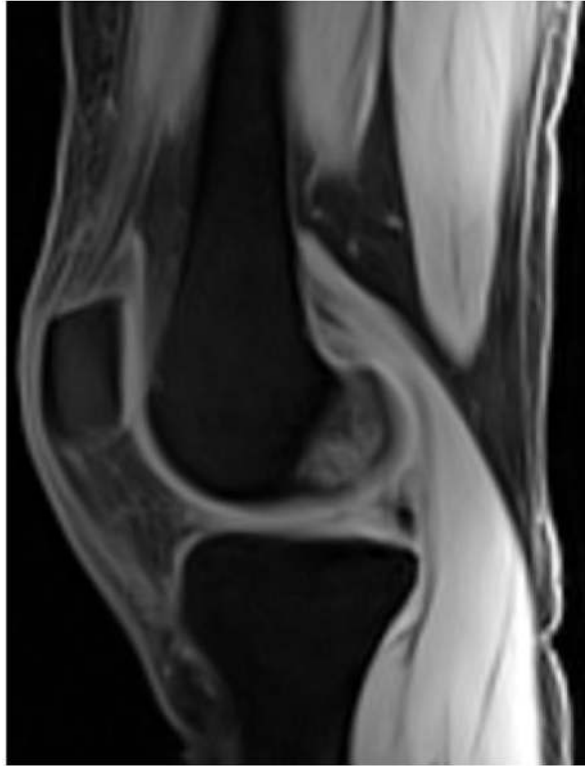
Water excitation technique. Sagittal VIBE (Siemens, Erlangen, Germany) MR image (TR, 20 msec; TE, 2.8 msec; FA, 15°) obtained with the water excitation technique shows a normal knee.
